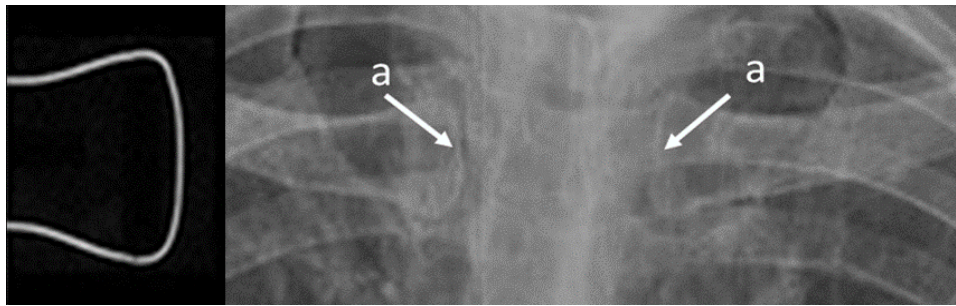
Radiograph of a 29-year-old patient showing stage 5 ossification: The estimated age = 27 years. a — convex edges without a visible scar.
